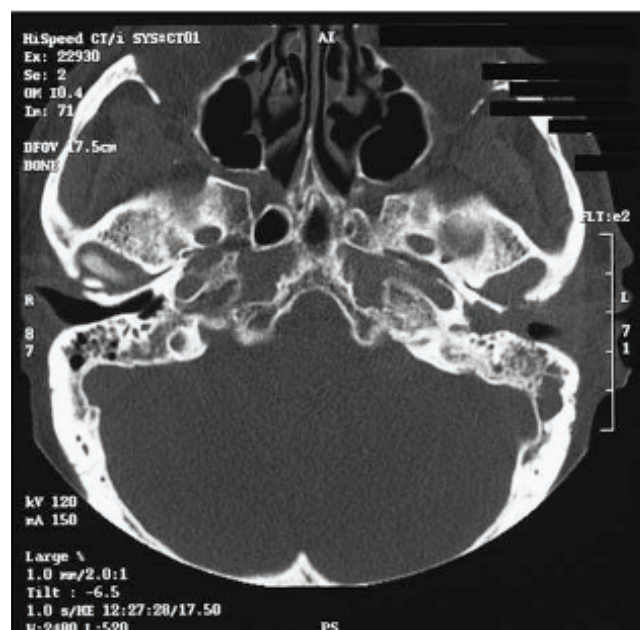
Adenoid cystic carcinoma of the left external auditory canal. High resolution axial CT of the skull base revealing soft tissue opacification of the left bony external auditory canal with perforation of the anterior wall extending into the temporomandibular joint. There is slight irregularity of the posterior wall of the bony external canal with opacification of the adjacent mastoid air cells. Courtesy of Professor Andy White, Perth Radiological Clinic, Perth, Western Australia.
